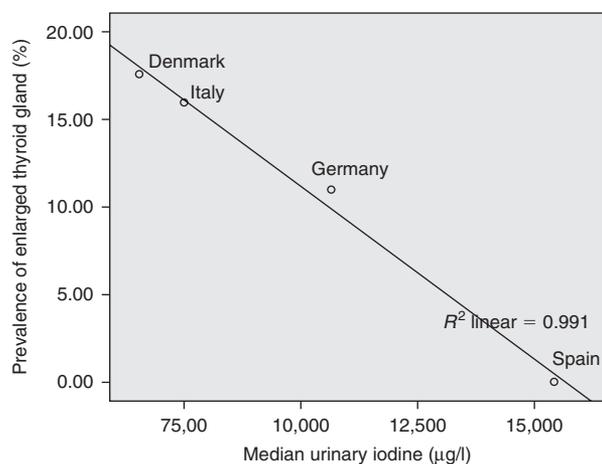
Iodine excretion and prevalence of enlarged thyroid gland in four European countries. The figure shows the iodine excretion ($\mu\text{g/l}$) and prevalence of thyroid enlargement determined by ultrasonography in four studies in European adults (Knudsen *et al.*, 2000; Maravall *et al.*, 2004; Valentino *et al.*, 2004; Brauer *et al.*, 2005).
